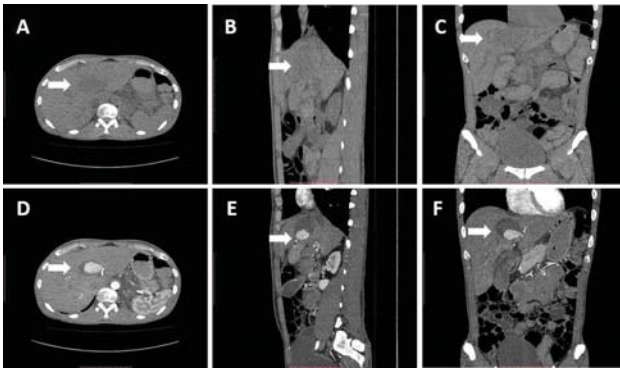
(A) Axial, (B) sagittal, and (C) coronal views from multi-slice computed tomography (MSCT) of the abdomen/pelvis show a non-enhanced extended hematoma in the middle segment of the left lobe of the liver. MSCT (D) axial, (E) sagittal, and (F) coronal views post-contrast show the passage of contrast into the arterial system and the liver injury (white arrows) as a pseudoaneurysm.
